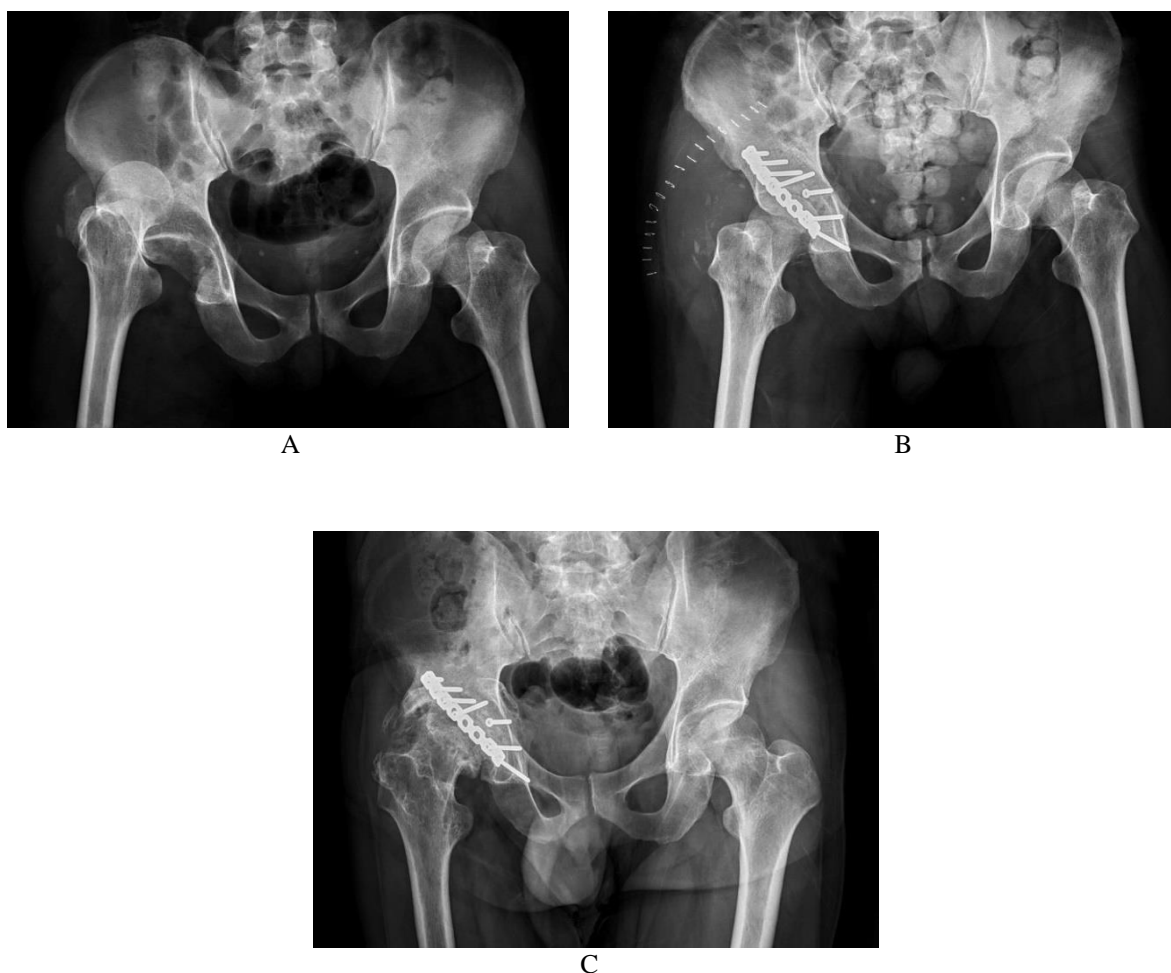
A 34 years old male. (A) Transverse fracture with posterior wall and posterior hip dislocation. (B) Post-operative film after open reduction and internal fixation. (C) Six month X-ray showing advance radiological change of hip joint and osteoarthritis. Radiological outcome classified as a Poor.
